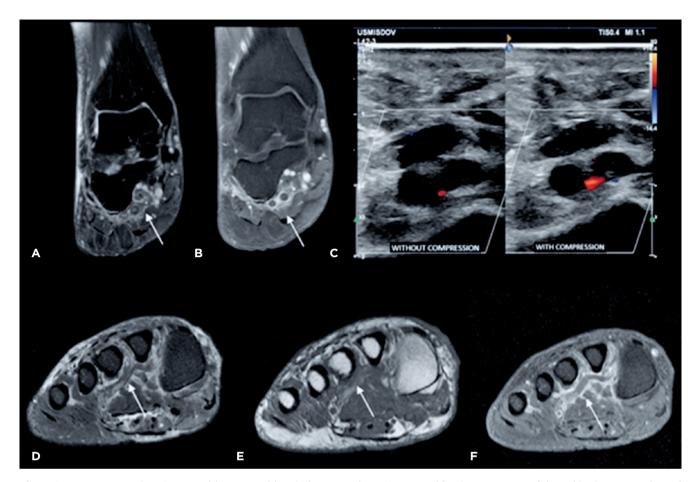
MRI sequences in a 47-year-old woman with pain for seven days. (A) coronal fs T2-w sequence of the ankle shows an enlarged lateral plantar vein and perivascular edema (open arrow). (B) coronal postcontrast fs T1-w sequence of the ankle shows a filling defect lateral plantar vein (open arrow) with enhancement of the perivascular planes (arrow). (C) ankle ultrasound showing echogenic material inside the bifurcated lateral plantar vein with no flow on the Doppler study, without the compression maneuver on the left, related to lateral plantar vein thrombosis. (D) coronal fs T2-w sequence of the midfoot shows plantar arch enlargement and perivascular edema (arrow). (E) coronal T1-w sequence of the midfoot shows material with a high signal within the plantar arch (arrow) associated with obliteration of the perivascular planes. (F) coronal postcontrast fs T1-w sequence of the midfoot shows a filling defect by contrast of the plantar arch with material with an intermediate signal inside that corresponds to the thrombus (arrow) associated with obliteration and enhancement of the perivascular planes.
